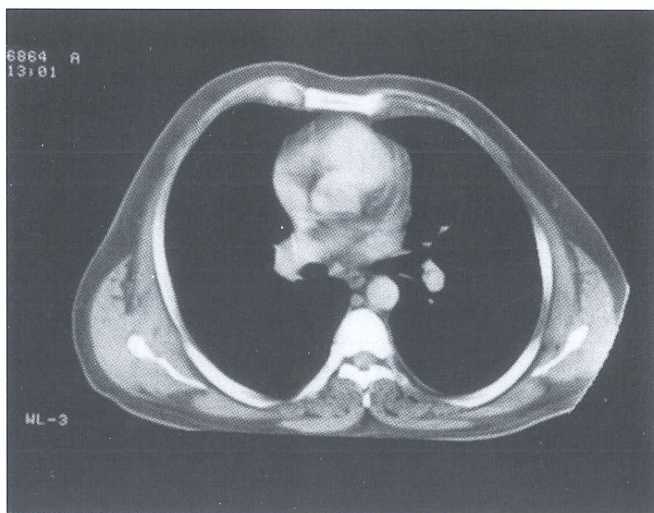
Thorax computed tomography obtained after catheters were removed: multiple mediastinal cysts lesser than 1cm and left pleural thickening.
